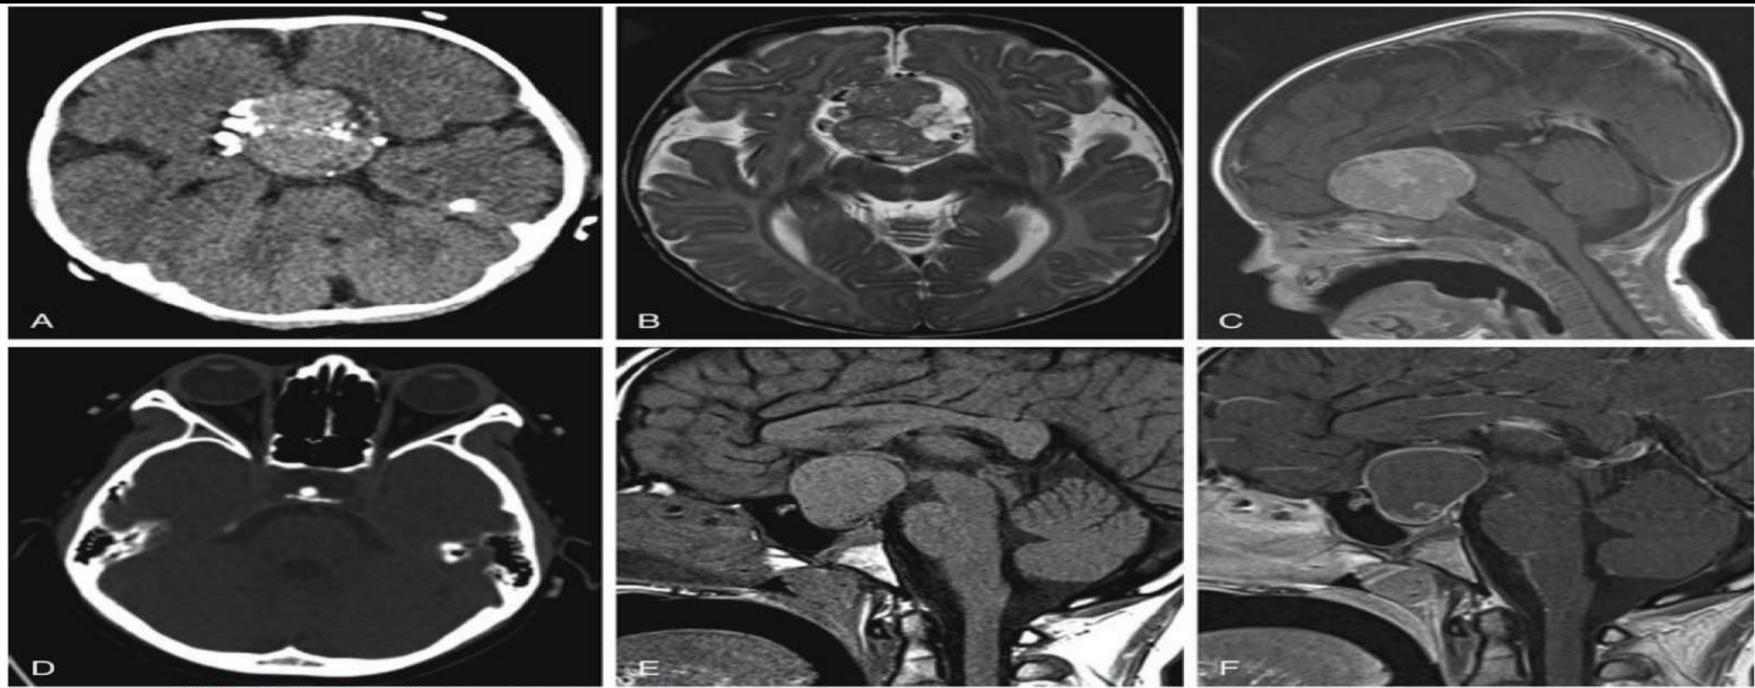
Two patients with craniopharyngioma. A-C, The 1st patient has a predominantly solid sellar-suprasellar mass with internal calcifications, which are seen best on the axial CT image (A). The mass is predominantly T2 isointense to hypointense and there are few T2 hyperintense cystic components along the left aspect of the mass (B). The solid components show enhancement (C). D-F, The 2nd patient has a predominantly cystic sellar-suprasellar mass with internal calcification (D), intrinsic T1 hyperintensity of the cyst contents (E), and a thin rim of postcontrast enhancement (F). Both lesions result in posterior and superior displacement of the optic chiasm. (From Seeburg DP, Dremmen MHG, Huisman TAGM: Imaging of the sella and parasellar region in the pediatric population, Neuroimag Clin N Am 27:99–121, 2017, Fig 2, p 103.)
